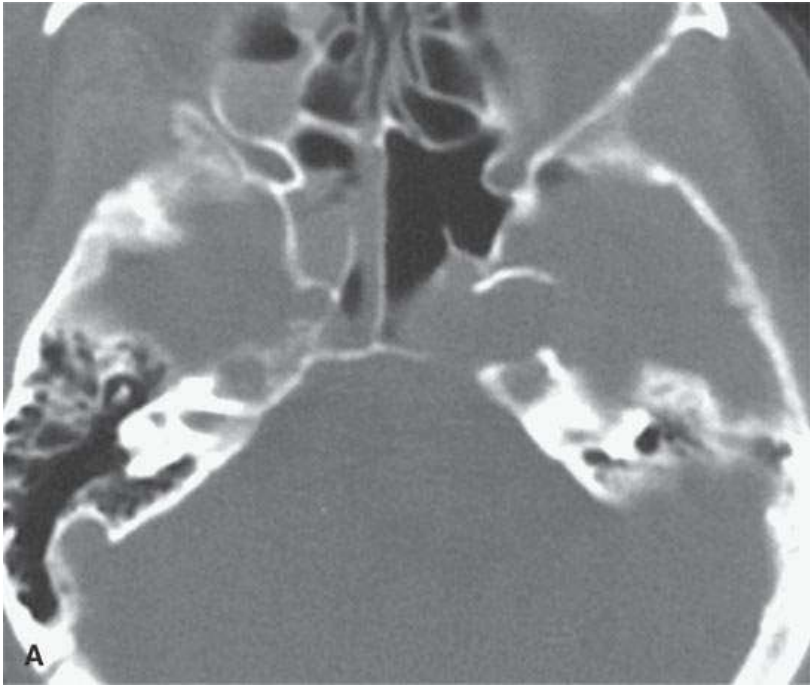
Computed tomography of the petrous apex and aneurysm, wherein recognizing calcification is critical to proper diagnostic decision making.
